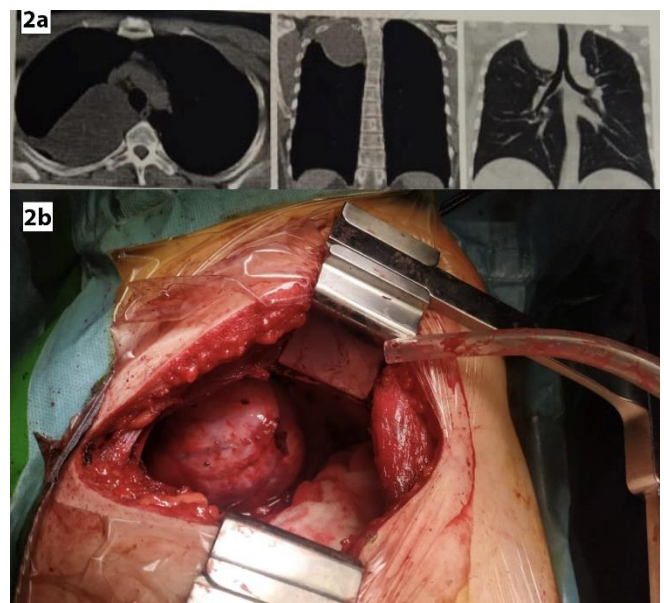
2a: axial and coronal CT sections demonstrating a right upper posterior mediastinal mass; 2b: posterolateral thoracotomy showing a sizable lesion with its relation to the surrounding
